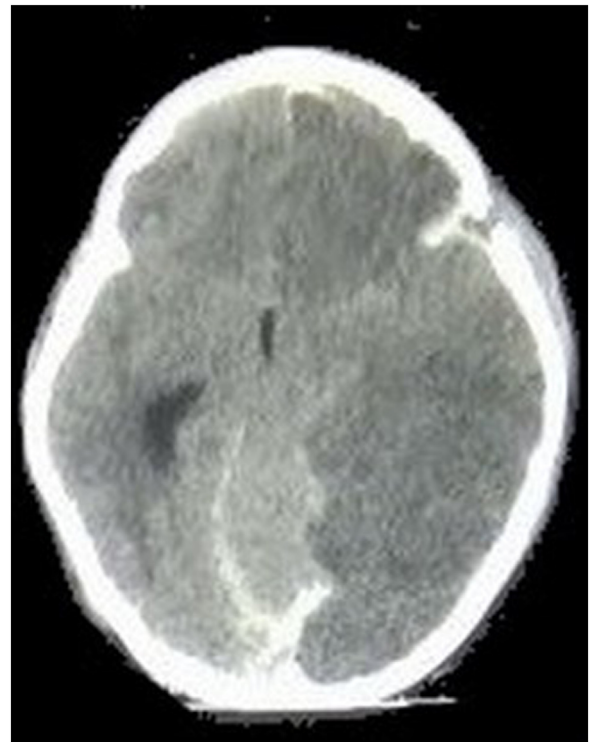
Axial section of a brain CT scan showing a stroke of the whole left carotid territory.
